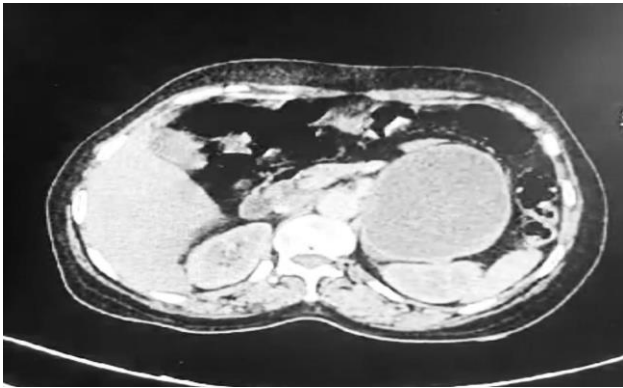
CT cross section (tumor highlighted).
